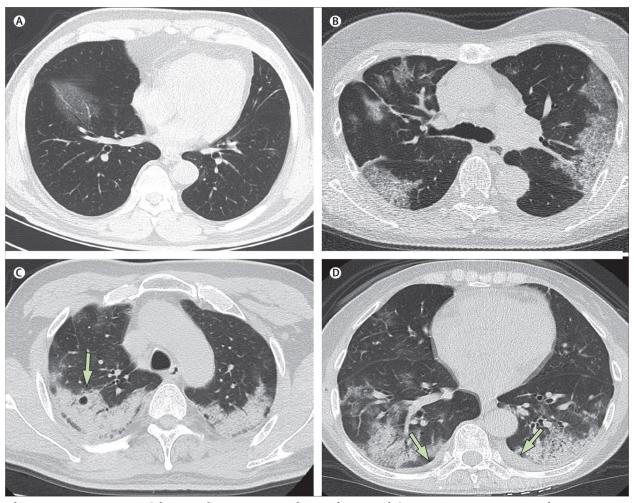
Transverse thin-section CT scans in patients with COVID-19 pneumonia
